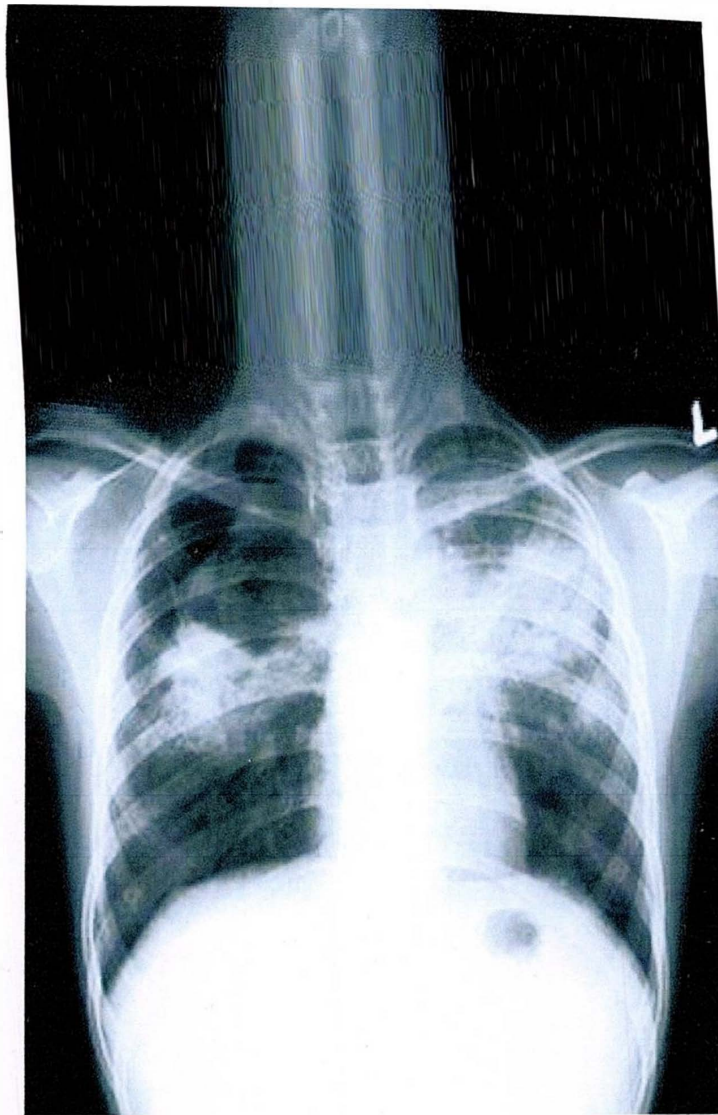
Chest radiograph of a pulmonary tuberculosis patient showing extensive infiltrates with evidence of cavitation in both lobes.
